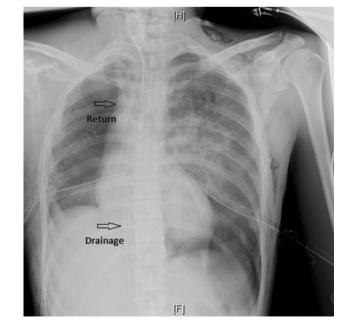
Chest X-Ray post-pneumonectomy at arrival in ISMETT. ECMO Cannulation
